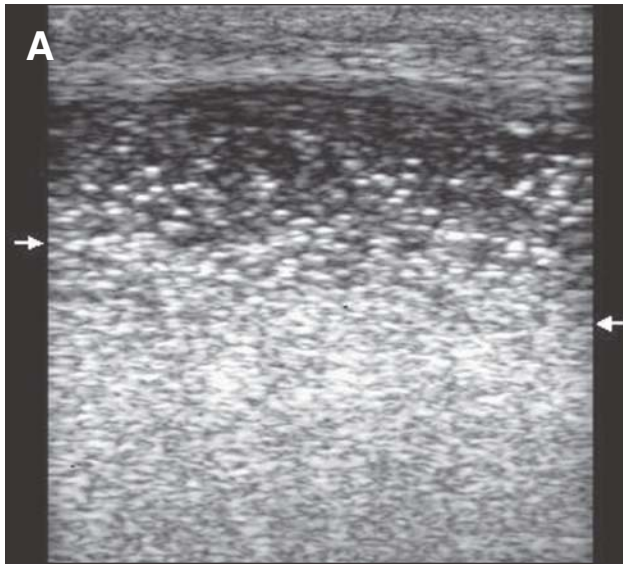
Short-axis cross-sectional ultrasonographic images of the right side of the scrotum (A) and right testicle (B) in a 7-year-old stallion evaluated for an abnormally large scrotum.
